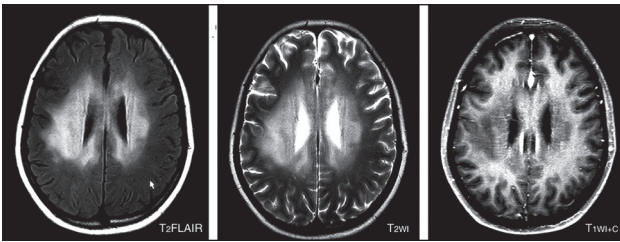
Disappearance of brain tumor after radiotherapy in magnetic resonance imaging
